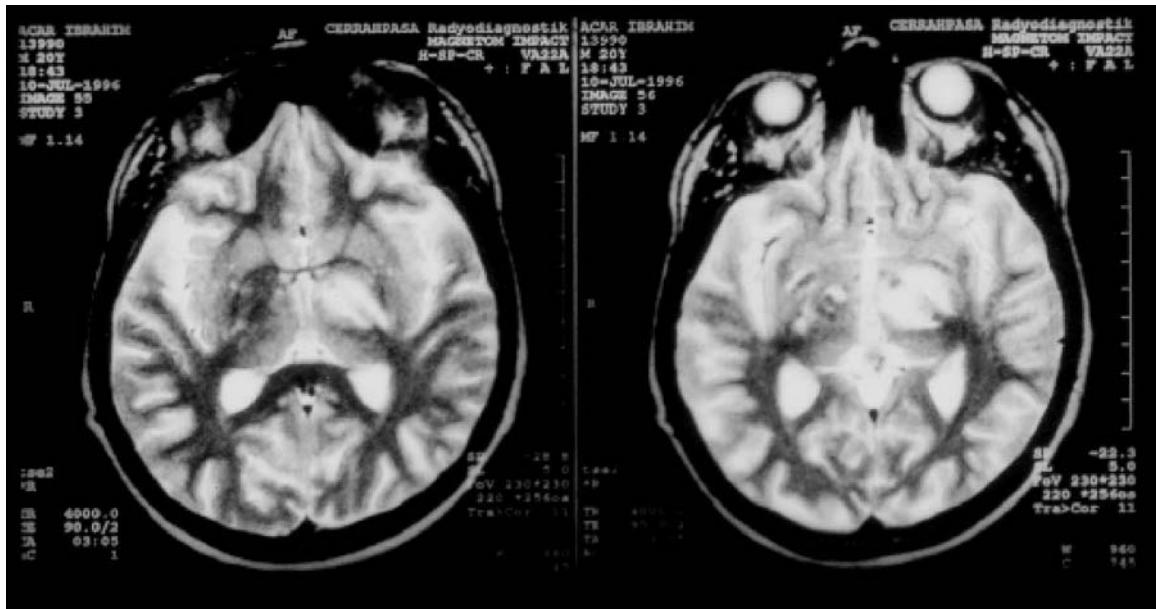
Neuro-Behcet disease: axial T2W images showing the most common pattern of CNS involvement as seen on MRI in a patient with intra-axial NBS. Involvement of the mesodiencephalic region, the most commonly affected region in intra-axial NBS, with extension to the basal ganglia and external capsule.
